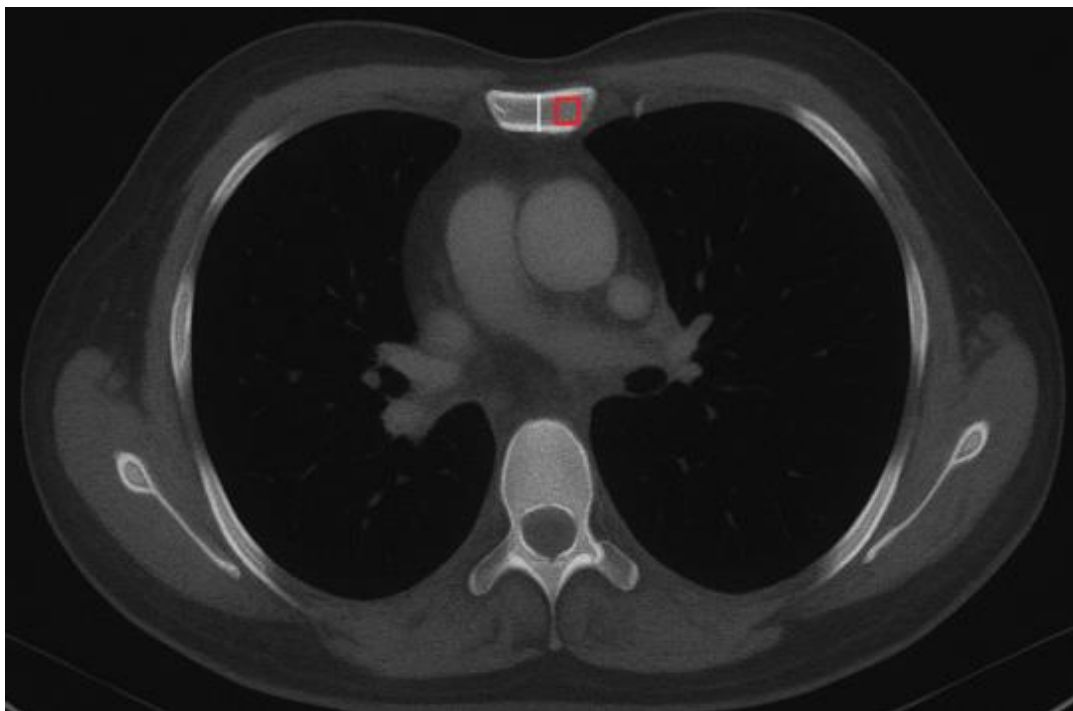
Preoperative axial CT chest demonstrating sternal thickness (white line) and cortical bone density measurement (ROI red box, expressed in Hounsfield Units > 450; considered normal).
